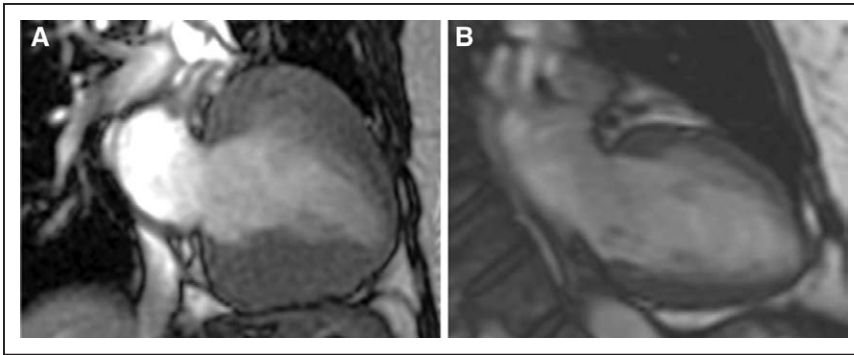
Representative cardiac magnetic resonance images from patients with refractory hypertension (A), demonstrating increase ventricular wall thickness with similar end-diastolic volumes when compared with patients with controlled resistant hypertension (B).
